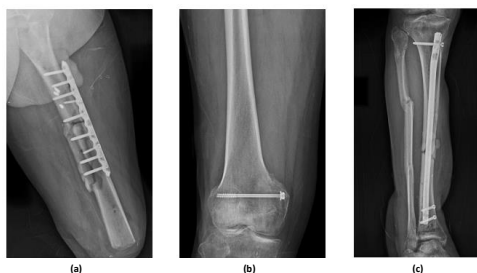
The plain film image showing non-union of left femur fracture, which was taken 10 months after initial injury; (b) The plain film showing union of right femur fracture; (c) The plain film images of right tibia and fibula fractures.
